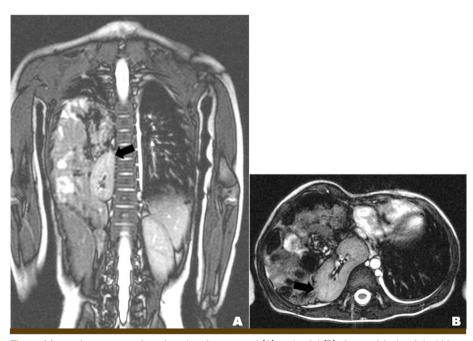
Magnetic resonance imaging showing coronal (A) and axial (B) views with the right kidney (arrow) and the small and large intestines protruding above the diaphragm on the same side.
